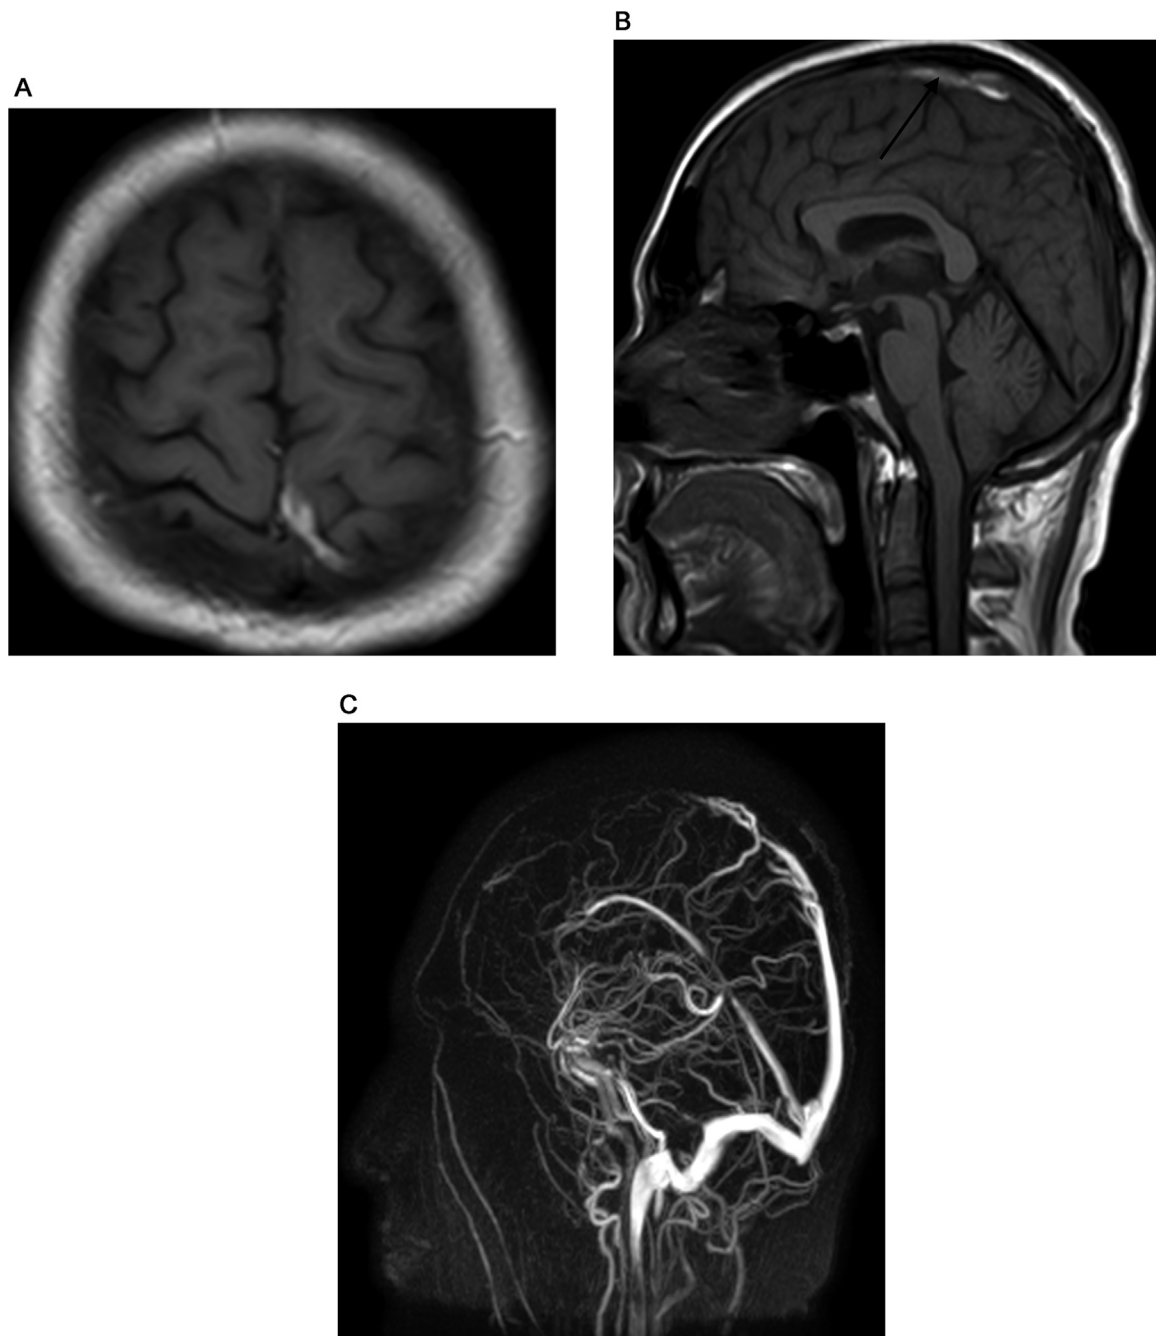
(A) Axial T1 weighted MRI image showing high signal intensity in the left vein of Trolard in the left high parietal lobe. (B) Midsagittal T1 weighted MRI image showing high signal intensity in superior sagittal sinus in the region of parietal convexity with loss of flow void (black arrow). (C) Sagittal 3D reconstruction of MRV image showing nonvisualization of left vein of Trolard and anterior aspect of the superior sagittal sinus with an irregular outline in the parietal region (black arrow).
